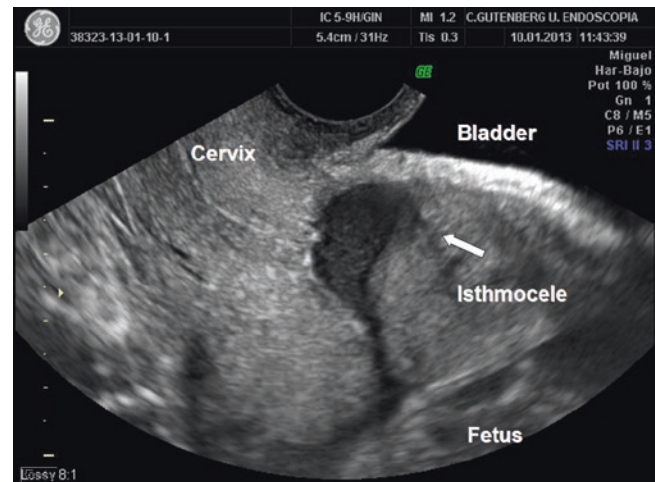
Ultrasound view of the cervix and low uterine segment
